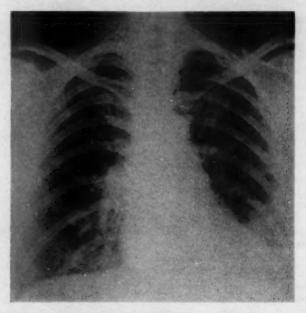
(case 4),—Roentgen appearance of the lungs one week before death. There are miliary fine soft densities, more in the lower lung fields.
